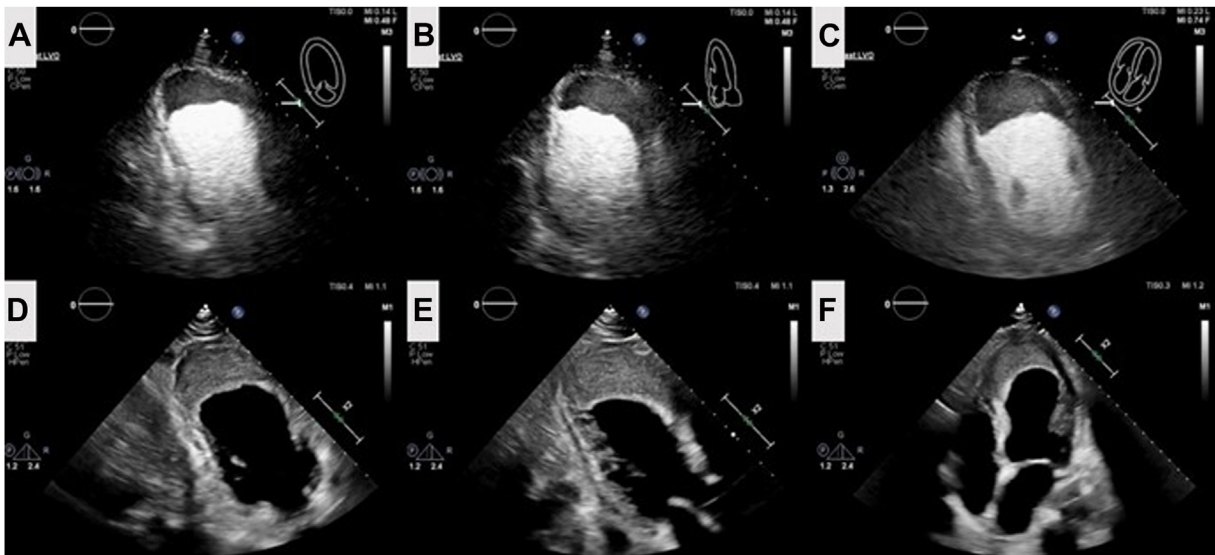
Two-dimensional TTE demonstrating a large apical LV thrombus. (A) Apical two-chamber view with ultrasound enhancing agent (UEA). (B) Apical three-chamber view with UEA. (C) Apical four-chamber view with UEA. (D) Apical two-chamber view without UEA. (E) Apical three-chamber view without UEA. (F) Apical four-chamber view without UEA.
